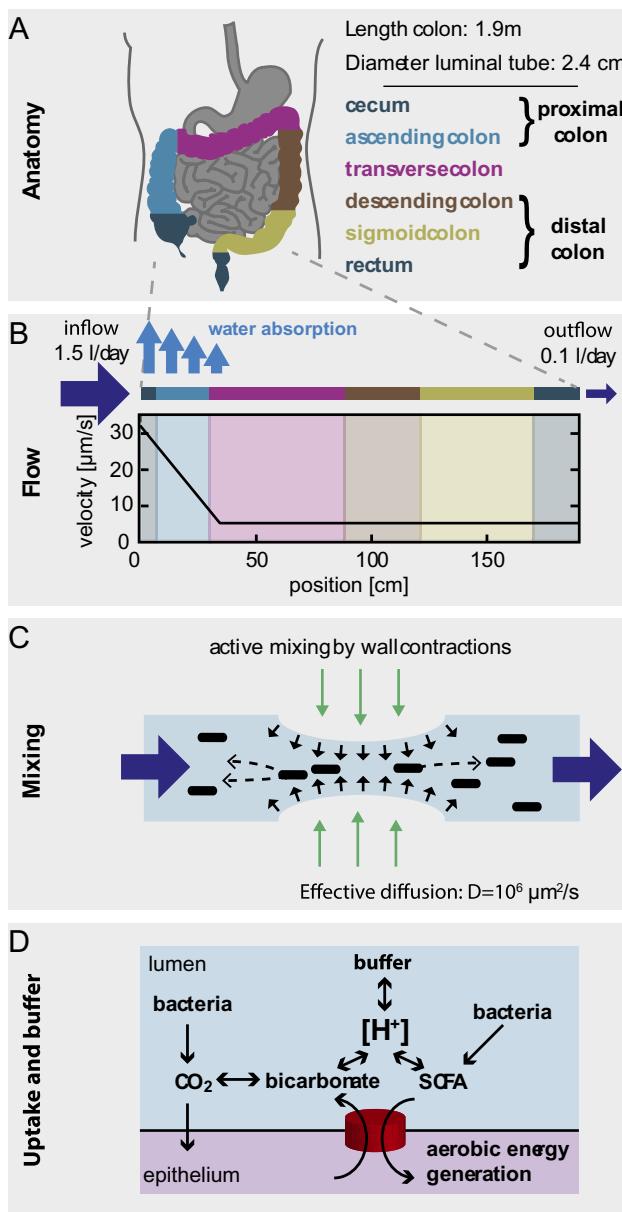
Physiological parameters of the human colon. (A) Anatomical dimensions. Based on measurements of human colonic anatomy during the autopsy, X-ray and CT imaging using contrast media, and magnetic resonance tomography imaging, Cremer et al. derived operational numbers for the lengths, surface areas, and luminal diameters of the different colonic segments. (B) Luminal flow. About 1.5 L of fluid reaches the proximal colon every day. The epithelium absorbs most of this volume, and only 100–200 mL/day exit the colon as feces. This continuous water uptake along the colon leads to a steep gradient in luminal flow rates. We calculated an average flow velocity of about 30 μm/s at the beginning of the colon that drops to about 5 μm/s by the end of the ascending colon. (C) Mixing of luminal contents. Contractions of the intestinal walls can generate local mixing. Based on data on the mixing of radiolabeled dyes in the large intestine, we derive that the measured distributions can be approximated by an effective diffusion constant of $D \sim 10^6 \mu\text{m}^2/\text{s}$, a value orders of magnitude higher than molecular diffusion. (D) Epithelial SCFA uptake, bicarbonate excretion, and buffer chemistry. Bacterial fermentation leads to the production of SCFAs, which are taken up by the gut epithelium and contribute to the host's energy intake. SCFA uptake is coupled to the excretion of bicarbonate, which, in equilibrium with CO_2 and other luminal components, buffers the luminal acidity ($\text{pH} = -\log[\text{H}^+]$). All calculations are based on the measured characteristics of epithelial transporters and the buffer capacity of the lumen. Credit: Fig. 2 of Cremer J, Arnaldini M, Hwa T. Effect of water flow and chemical environment on microbiota growth and composition in the human colon. Proc Natl Acad Sci U S A 2017;114:6438–43. <https://doi.org/10.1073/pnas.1619598114>.
